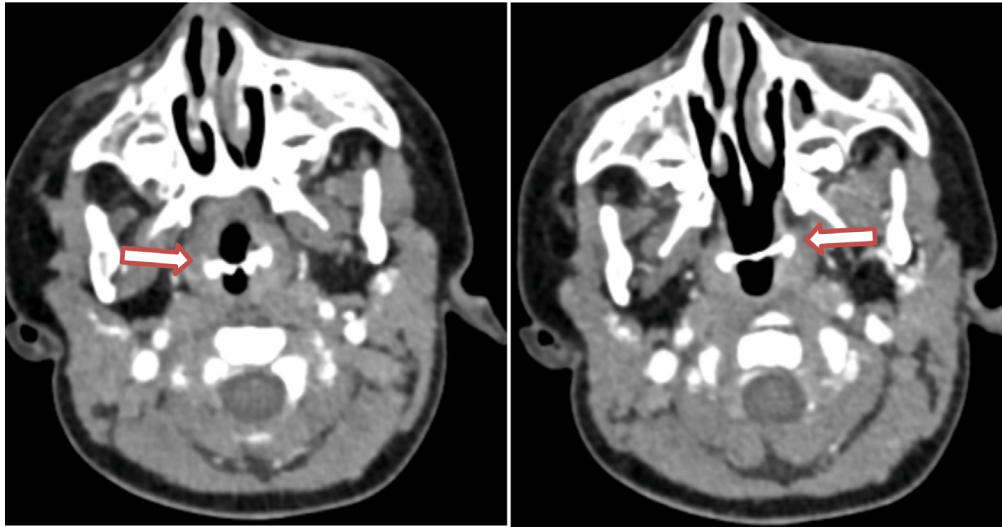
(A and B) Computed tomography scan of nose and paranasal sinuses axial cut showing the location of the foreign body (white arrows) in the nasopharynx.
